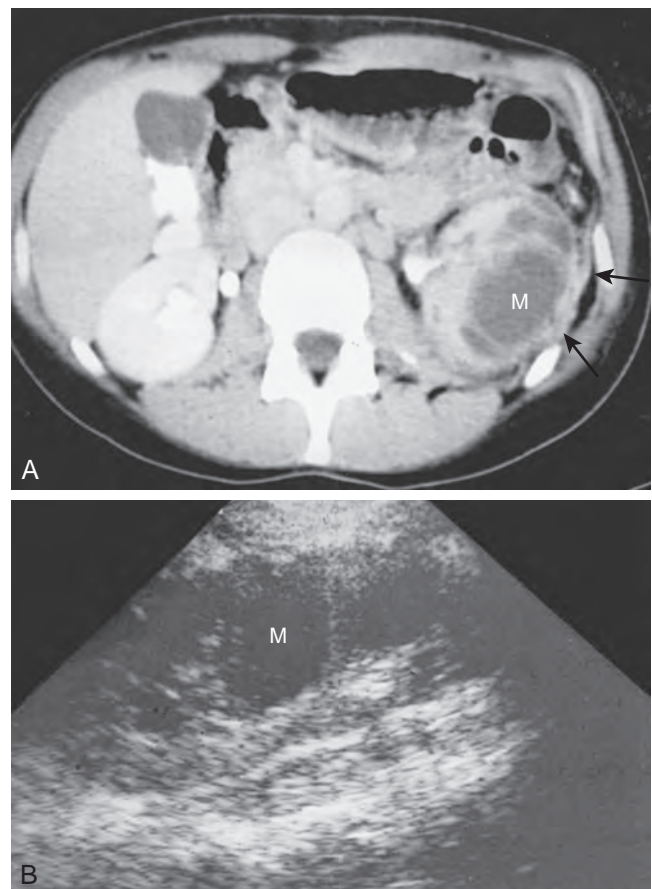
Chronic renal abscess. A, Enhanced computed tomography scan shows an irregular septated low-density mass (M) extensively involving the left kidney. Note thickening of perinephric fascia (arrows) and extensive compression of the renal collecting system. Findings are typical of renal abscess. B, Ultrasound longitudinal image demonstrates a septated hypoechoic mass (M) occupying much of the renal parenchymal volume.
